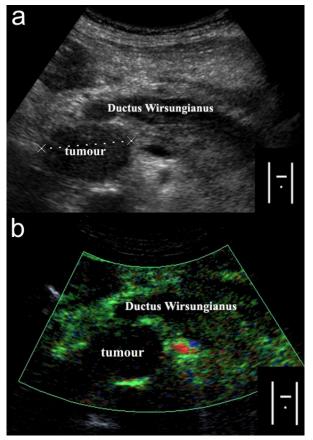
Pancreatic adenocarcinoma at conventional (a.) and echo-enhanced sonography (b.). a. Low-echo tumor with lobulated margins and dilatation of Wirsung's duct. b. Poorly vascularized lesion compared to the surrounding tissue.
